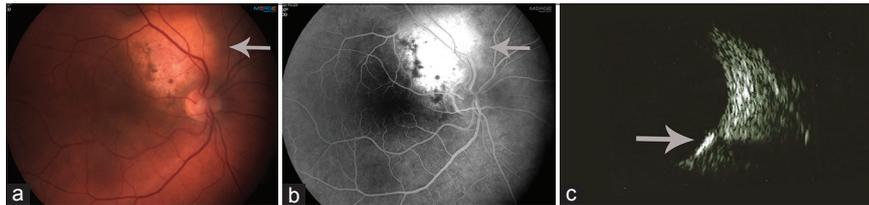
Choroidal osteoma demonstrated by color fundus photography (a), fluorescein angiography (b), and ultrasonography (c)
